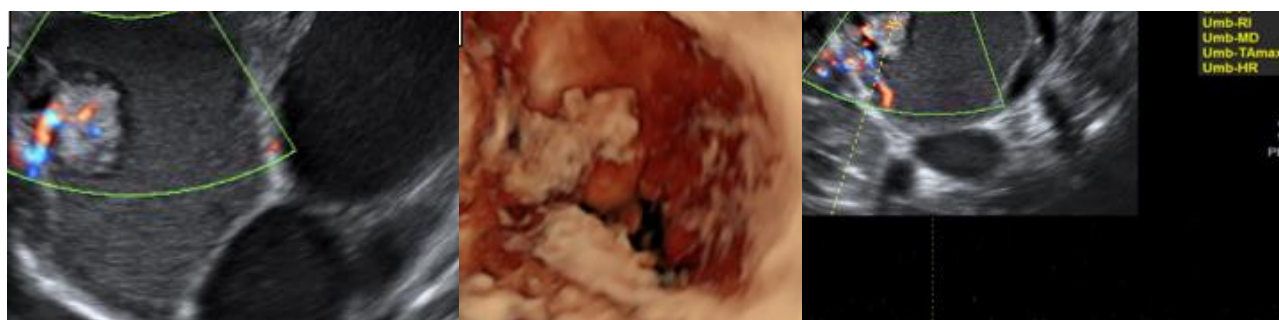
2D/3D Color Doppler ultrasonography of malignant alteration of endometriosis. Papillary projection and low Ri on papillary blood vessel.(a,b, c,)
